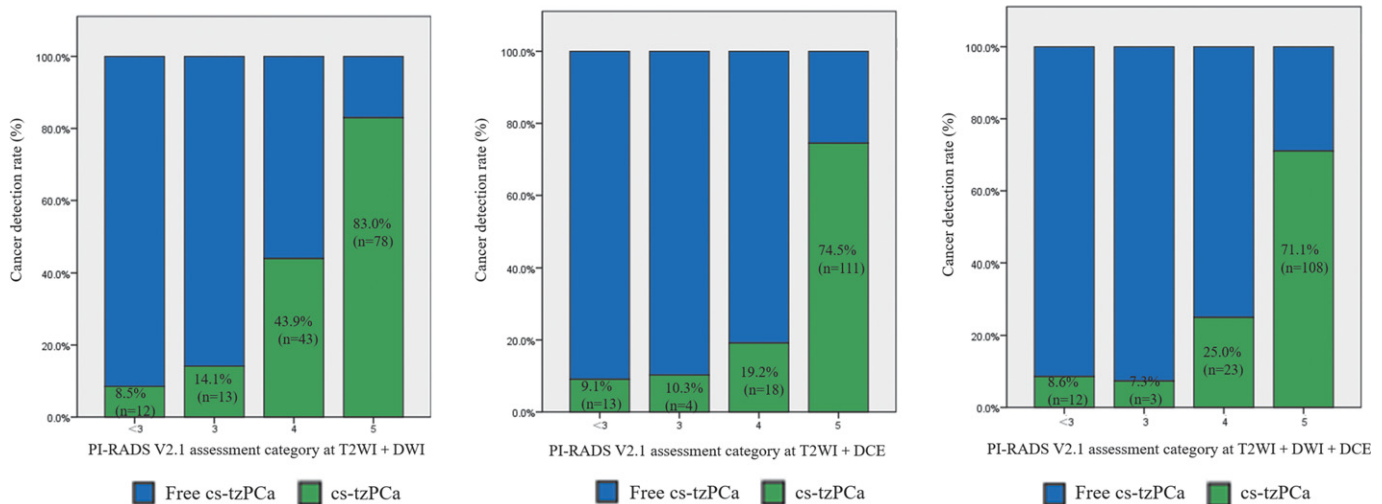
Histograms showing cancer detection rates of cs-tzPCa based on the T2-weighted imaging (T2WI) + diffusion-weighted imaging (DWI), T2WI + dynamic contrast-enhancement (DCE), and T2WI + DWI + DCE.
